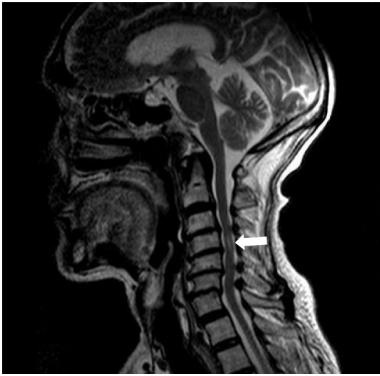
Magnetic resonance imaging of the cervical spine. Cervical syringomyelia at C4 (white arrow); cervical disc herniation and spinal stenosis from the C3 to C7 Levels.
